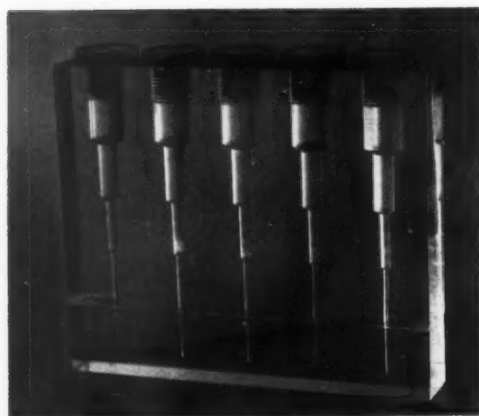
Ter-Pogossian contrast test object. The cylindrical holes in the plastic block are identical in their varying calibers. These are filled with opaque contrast solutions of different dilutions to test their radiographic perceptibility.
